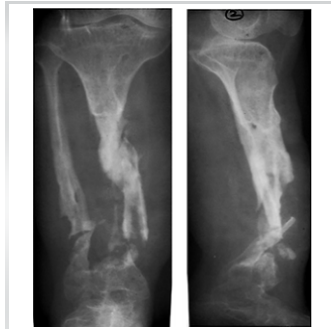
Pre-operative X-ray showing infected non-union right tibia.
